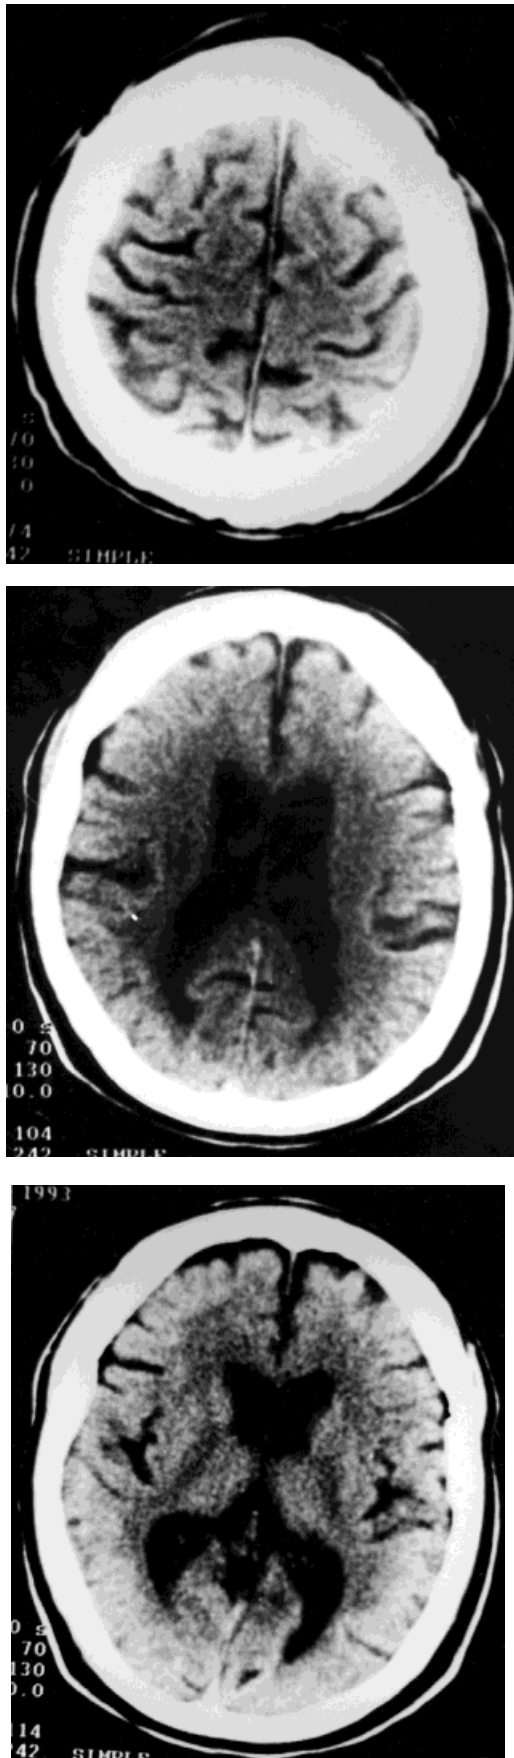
Brain CT-SCAN findings.
